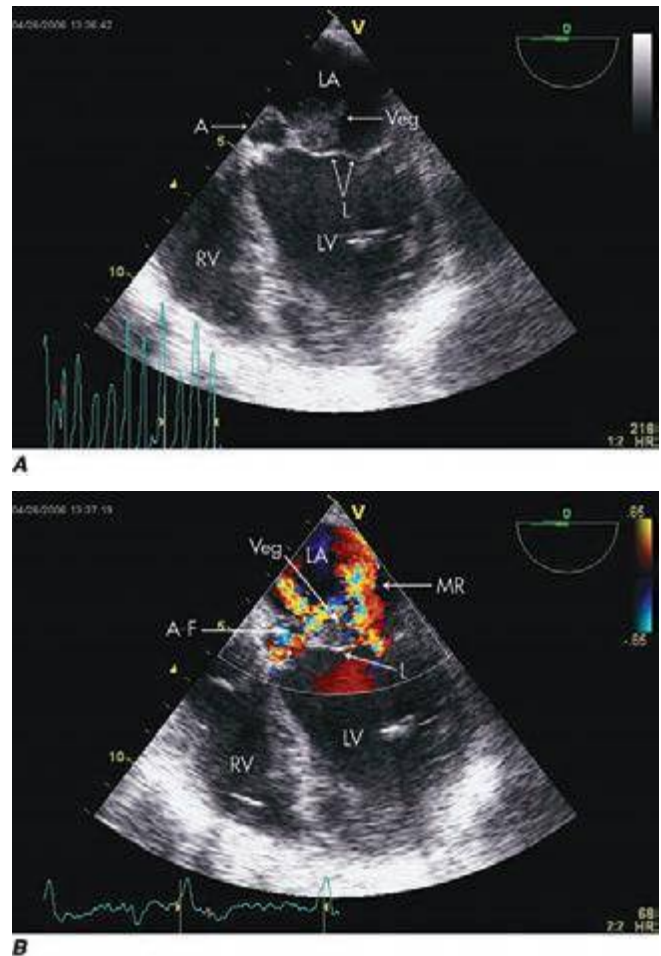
Imaging of a mitral valve infected with *Staphylococcus aureus* by low-esophageal, four-chamber-view, transesophageal echocardiography (TEE). A, Two-dimensional echocardiogram showing a large vegetation with an adjacent echolucent abscess cavity. B, Color-flow Doppler image showing severe mitral regurgitation through both the abscess-fistula and the central valve orifice. A, abscess; A-F, abscess-fistula; L, valve leaflets; LA, left atrium; LV, left ventricle; MR, mitral central valve regurgitation; RV, right ventricle; veg, vegetation. (With permission of Andrew Burger, MD.)
